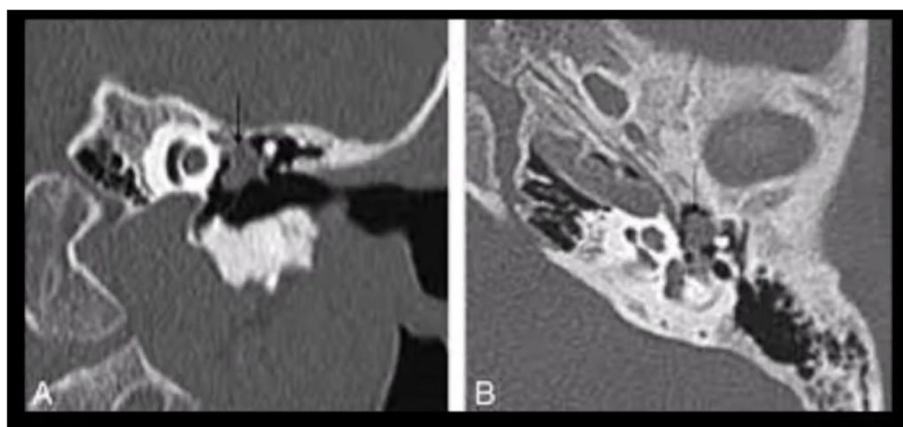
CT scan of petrous bone shows middle ear cholesteatoma. A Coronal view. B Axial view
